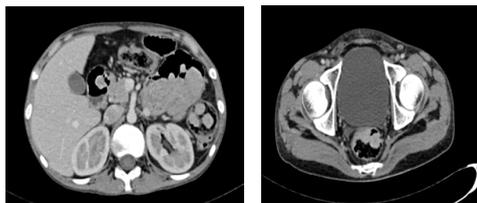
CT Abdomen showing multiple polyposis of stomach, duodenum, colon and rectum
